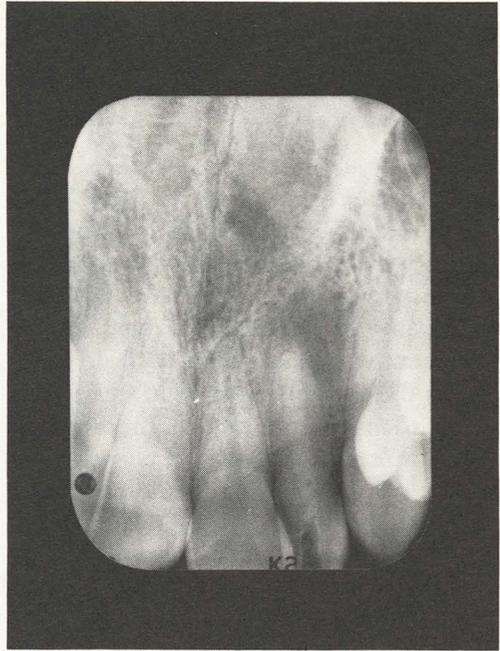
Radiograph confirming proper apical placement of CaOH paste.
